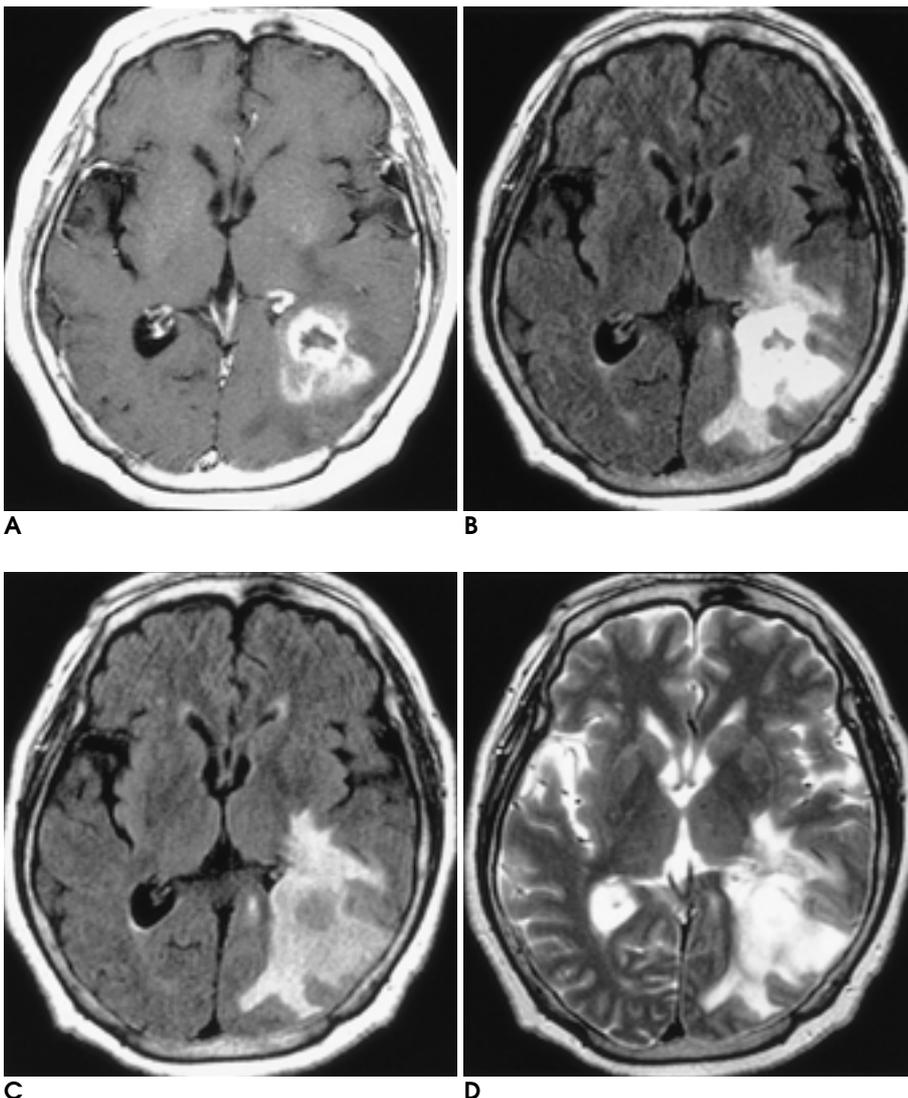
A 67-year-old man with glioblastoma. Contrast-enhanced T1-weighted (A) image shows an irregular enhancing mass in the left temporal lobe. The conspicuity of tumor is similarly better on contrast-enhanced T1-weighted (A) and fast FLAIR image (B) than on fast FLAIR (C) and T2-weighted image (D). Contrast-enhanced fast FLAIR image also shows clear distinction of enhancing tumor and surrounding edema.
